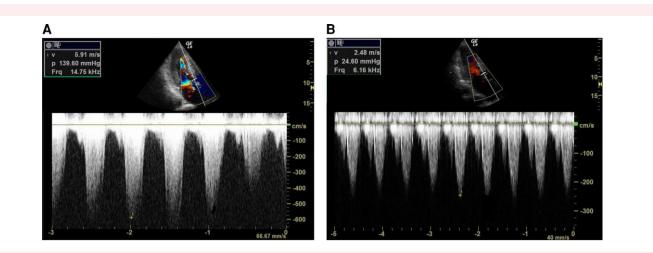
(A) The initial pulse wave doppler ultrasound of the left ventricular outflow tract. The maximum peak pressure gradient was measured at 139.6 mmHg. (B) The pulse wave doppler ultrasound of the left ventricular outflow tract after intravenous propranolol and cibenzoline. The maximum peak pressure gradient decreased to 24.6 mmHg.
